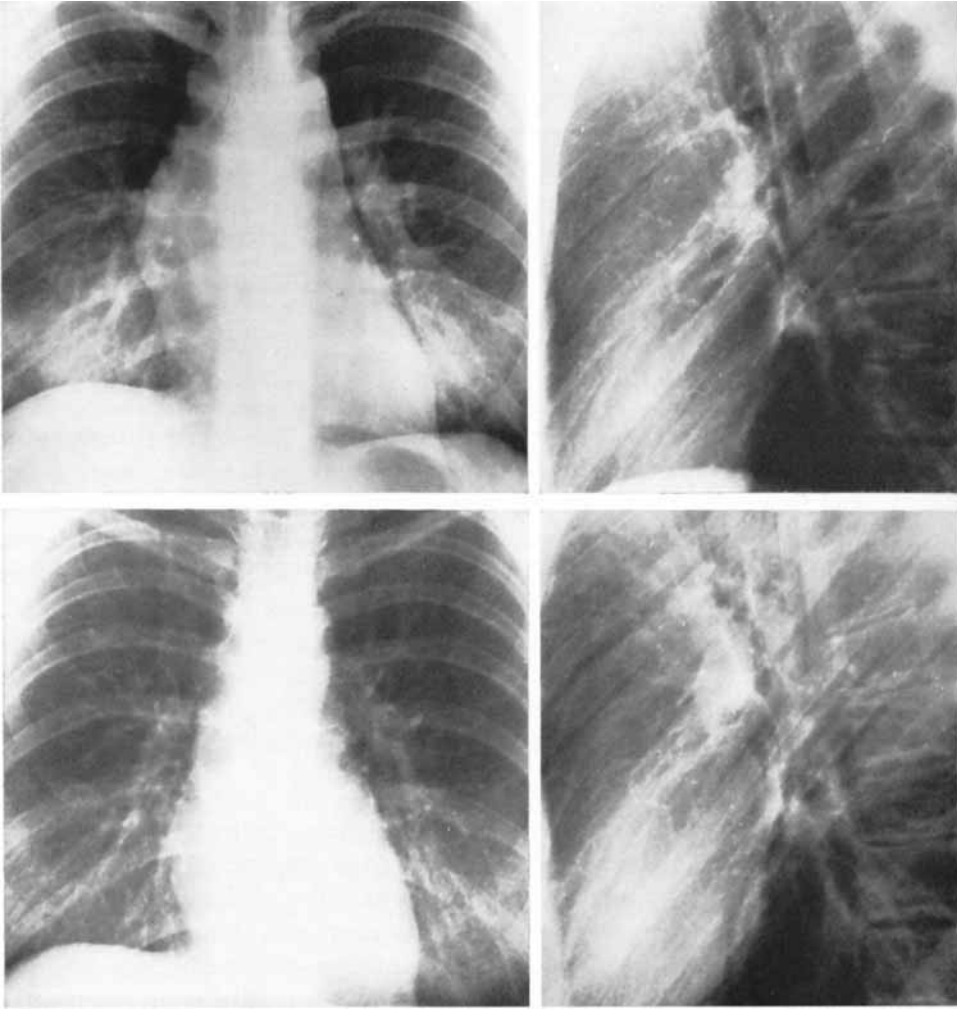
Frontal and lateral roentgenograms of patient No. 6. *Upper views:* At the beginning of mantle treatment. Widening of superior mediastinum, especially to the right, with lymphomas in the right hilum. *Lower views:* At the end of mantle treatment. Marked regression in the size of the lymphomas but persistent widening of the superior mediastinum.
